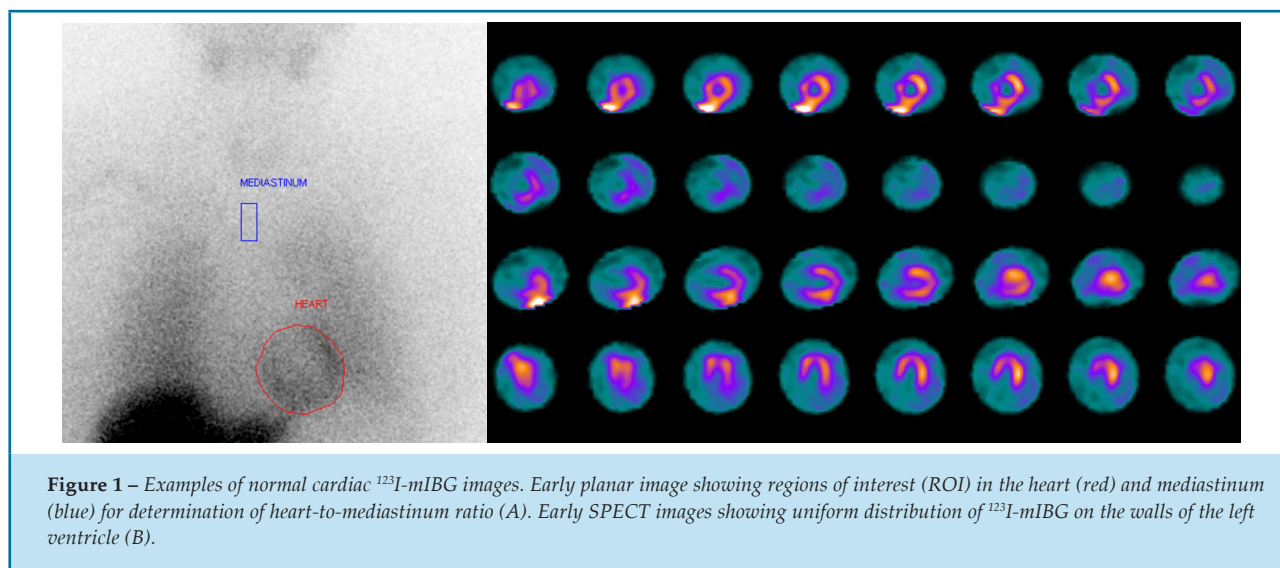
Examples of normal cardiac ^{123}I -mIBG images. Early planar image showing regions of interest (ROI) in the heart (red) and mediastinum (blue) for determination of heart-to-mediastinum ratio (A). Early SPECT images showing uniform distribution of ^{123}I -mIBG on the walls of the left ventricle (B).
